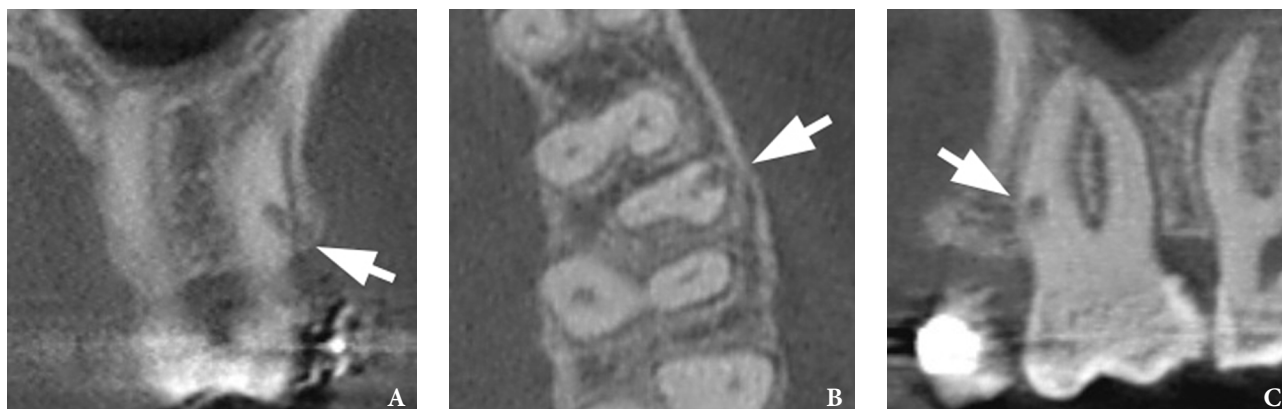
CT scans (A: coronal; B: axial; C: panoramic) shows area of drilling (arrow) causing the damage to the hard and soft tissues of the tooth root. Note proximity of the insertion hole to the first mesiobuccal (MB1) canal of the tooth 2.7.
